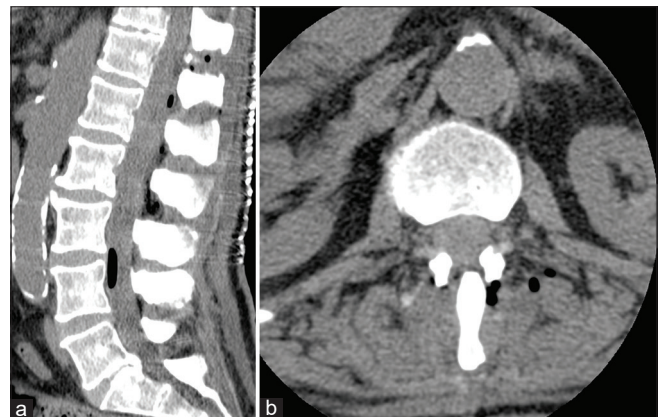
(a) Lumbo-sacral computed tomography showing a post-operative laminoplasty and excision of the previous lesion; sagittal plane (b) post-operative, axial plane.
